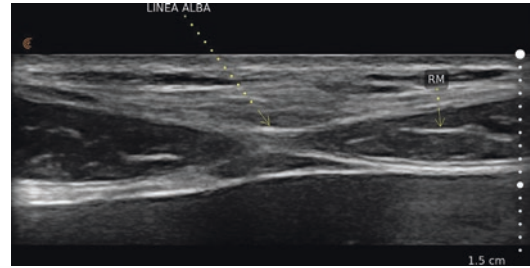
Grayscale ultrasound image of the normal appearance of the abdominal midline with transducer oriented transversely just above the umbilicus. RM is rectus abdominis muscle
